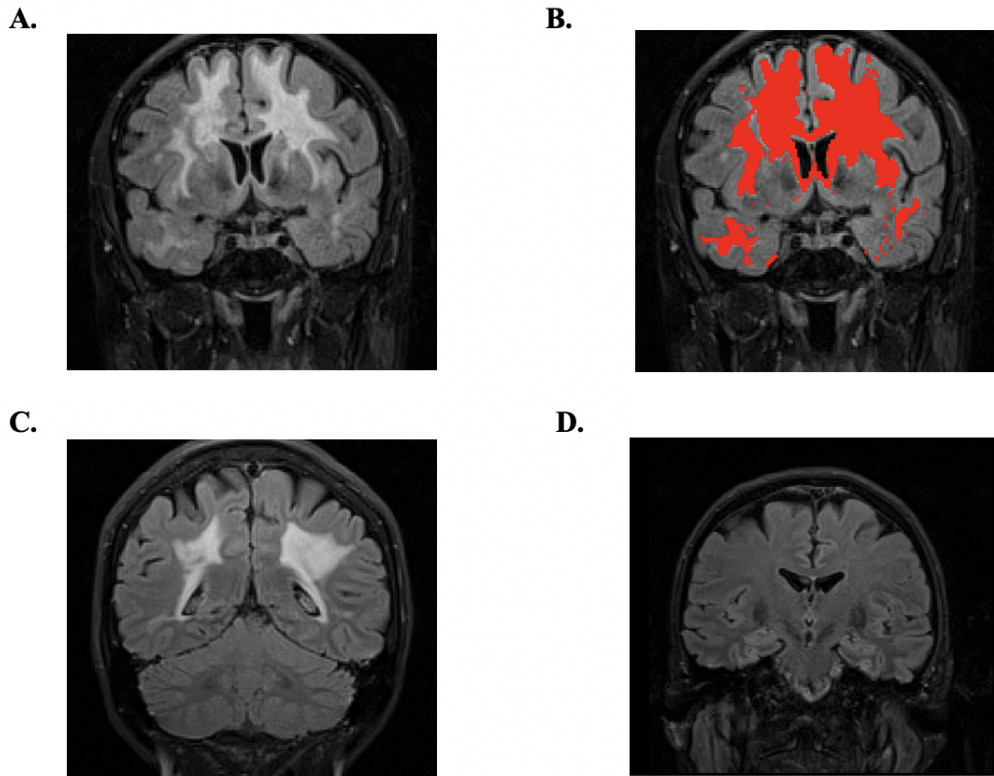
(A and C) Coronal sections of T2 FLAIR MR images of two different CADASIL patients. The white matter hyperintensities are obvious and extensive. (B) Same patient image as A, but with a BIANCA mask applied, as indicated in red. (D) T2 FLAIR MR image of a healthy control subject with normal signal intensity in white matter areas, suggesting no white matter hyperintensities.
